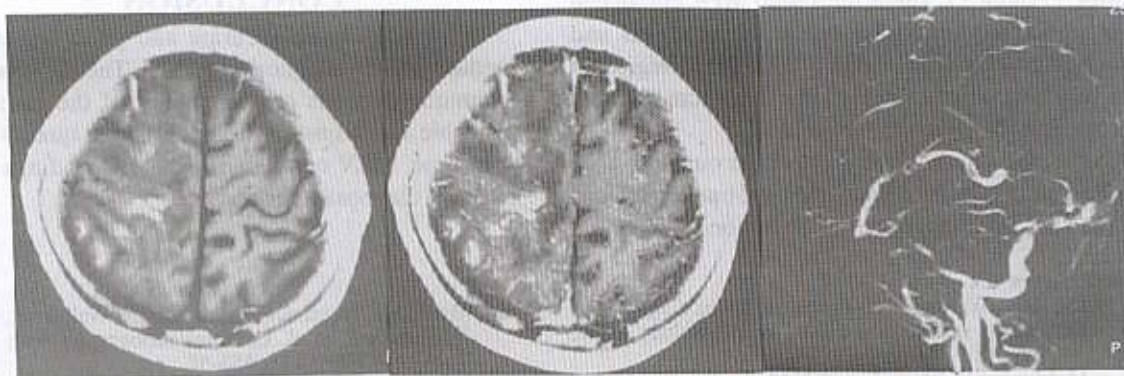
MRI (A: pre-, B: post- Gd-enhanced) and MRV (C) of a patient with history of systemic lupus show hemorrhagic infarction of the right parietal lobe and irregular loss of flow signal of the SSS. Note the enhancement of the SSS with no filling defect in B.
